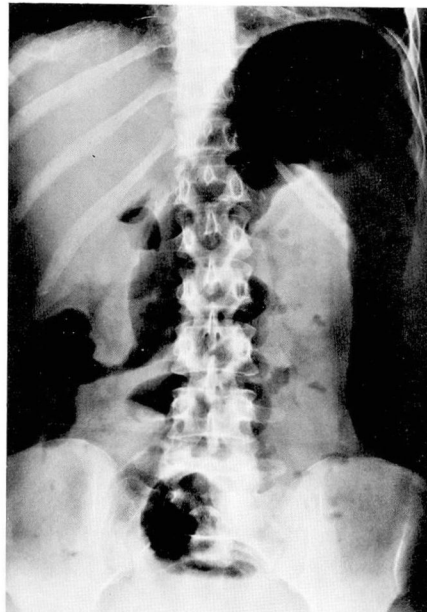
Roentgenogram of abdomen, August 1971. Toxic megacolon, with dilatation of colon maximal in splenic flexure.
